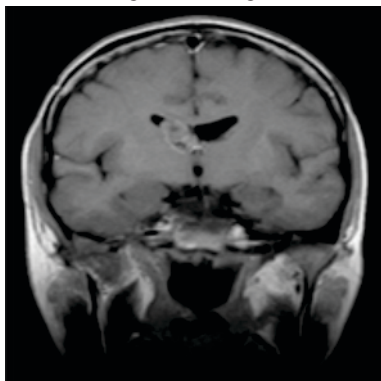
MRI, Coronal FatSat contrast enhanced image showing Subependymal Giant cell Astrocytoma in frontal horn of right lateral ventricle.
